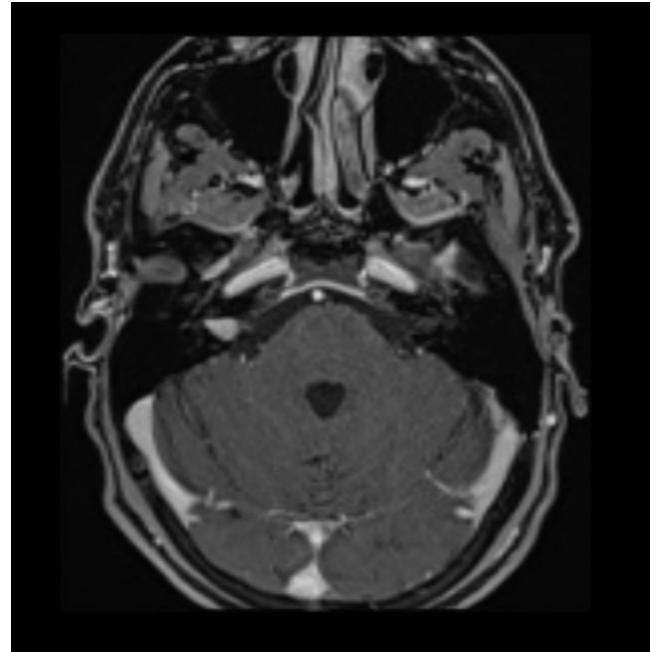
Contrast-enhanced MRI documenting presence of pure intracanalicular vestibular schwannoma, T1 according to Samii classification from 2007.
